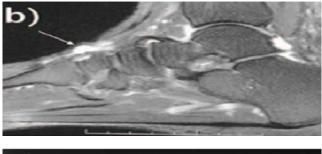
Osteosarcoma of the calcaneus in a 17-year-old female. Figure A - CT scan showed increased bone density of the calcaneus and a soft tissue extension with periosteal reaction. Figure B - MRI showing a low signal in bone and soft tissue extension on T1 coronal view. Figure C - Intense tumor enhancement on T2 fat sat injected sequences.
